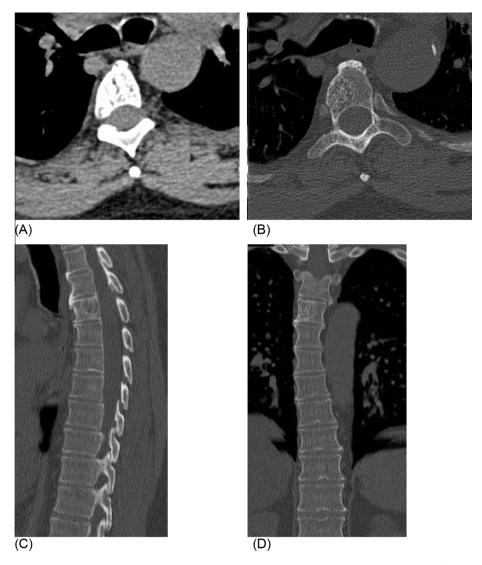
Axial CT sections of the dorsal spine in (A) soft tissue window setting and (B) bone window setting with reconstructed CT images in (C) sagittal plane and (D) coronal plane showing focal scoliotic deformity with convexity to the right side and altered bony texture of the right aspect of D4 vertebra with no cortical interruption or structural collapse.
